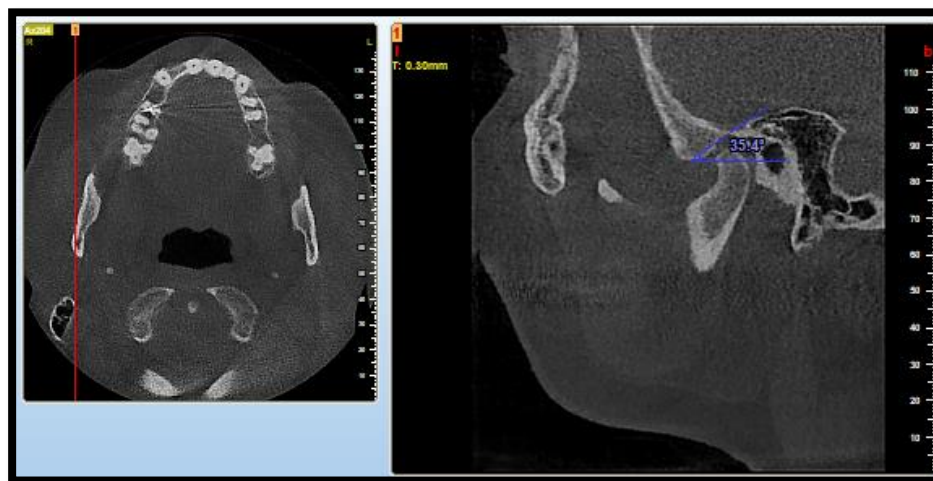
The measurement of articular eminence inclination in right side of 33 years old female on CBCT in sagittal section by method (top-roof line).
